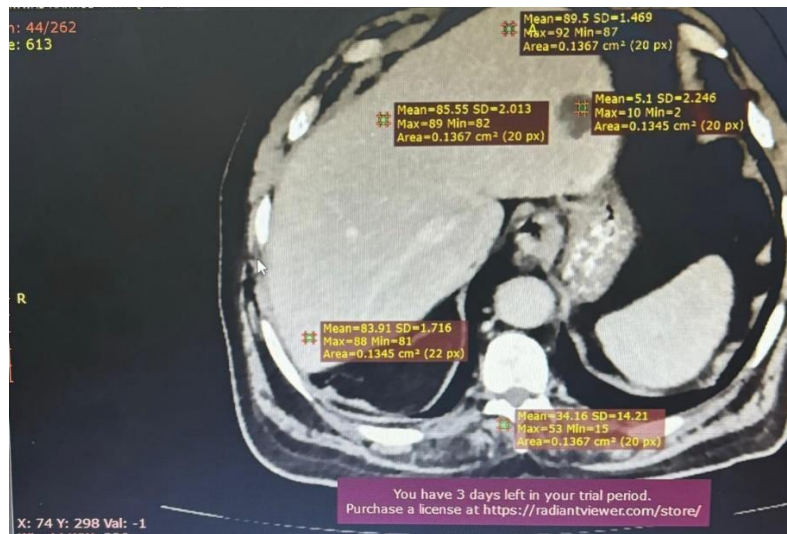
Axial view for liver CT scan for a patient with hemangiomas liver disease
